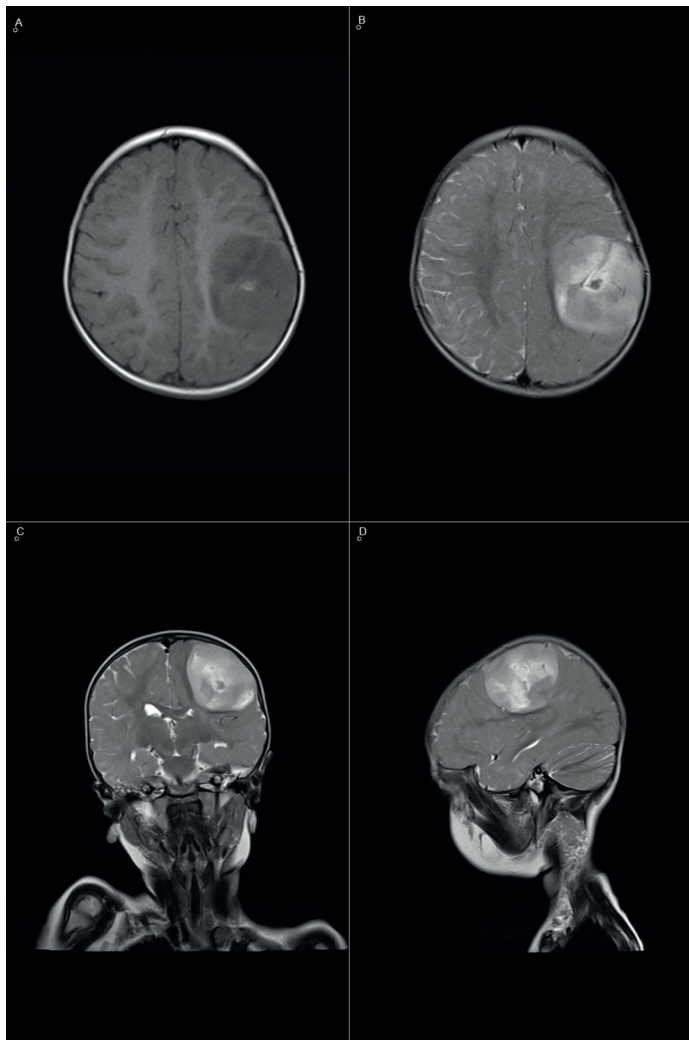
A. Axial T1-weighted image B. Axial T2-weighted image C. Coronal T2-weighted image D. Sagittal T2-weighted image. A 6 × 5.5 × 5 cm lesion in the left parietal lobe, mildly hypointense in T1 weighted images and heterogeneous hyperintense in T2 weighted images. T1 hyperintense, T2 hypointense focuses at the central part of lesion
